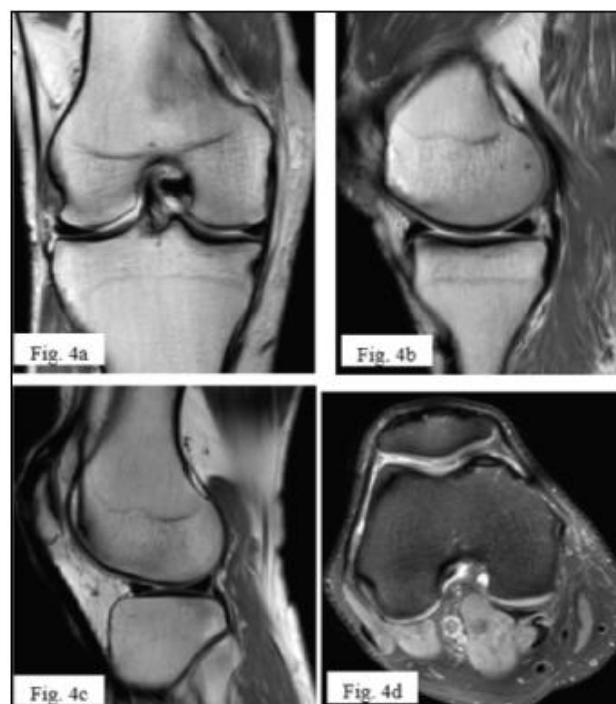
A 49 year old male patient presented with complaint of right knee pain since 1 month. MRI of the knee: 4a- PD coronal, 4b- PD sagittal showing medial femoral condyle, 4c- PD sagittal showing lateral femoral condyle, 4d- PD SPAIR axial. Both medial and lateral compartment appear smooth in outline and show normal signal intensity. Articular and patellar cartilage appears smooth in outline and shows maintained thickness.
